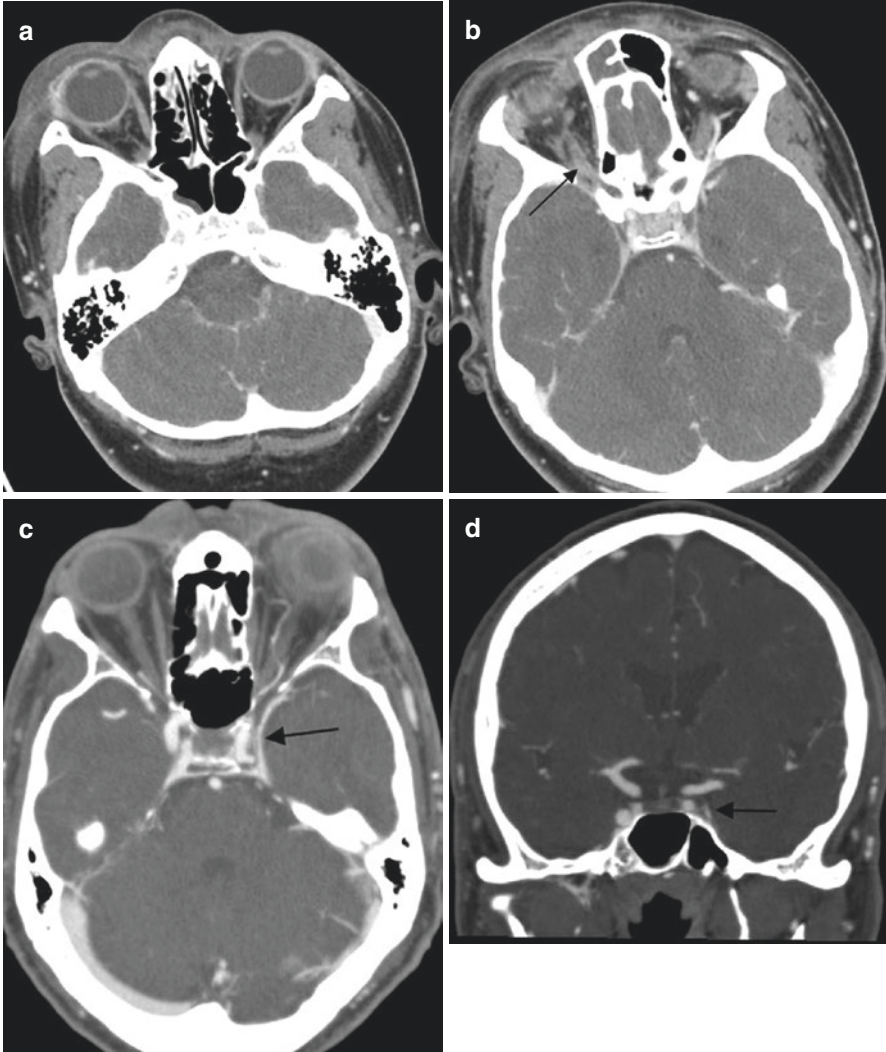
A patient with right preseptal cellulitis (a) and postseptal cellulitis has increased size of the hypodense right superior ophthalmic vein with perivenular inflammatory stranding (*arrow*) on contrast-enhanced axial CT scan of the orbits (b). Intracranial CTA, which was performed on a different patient with multiple cranial neuropathies and left orbital cellulitis, shows left lateral dural enhancement (*arrows*) on the (c) and coronal (d) planes, consistent with cavernous sinus thrombosis
